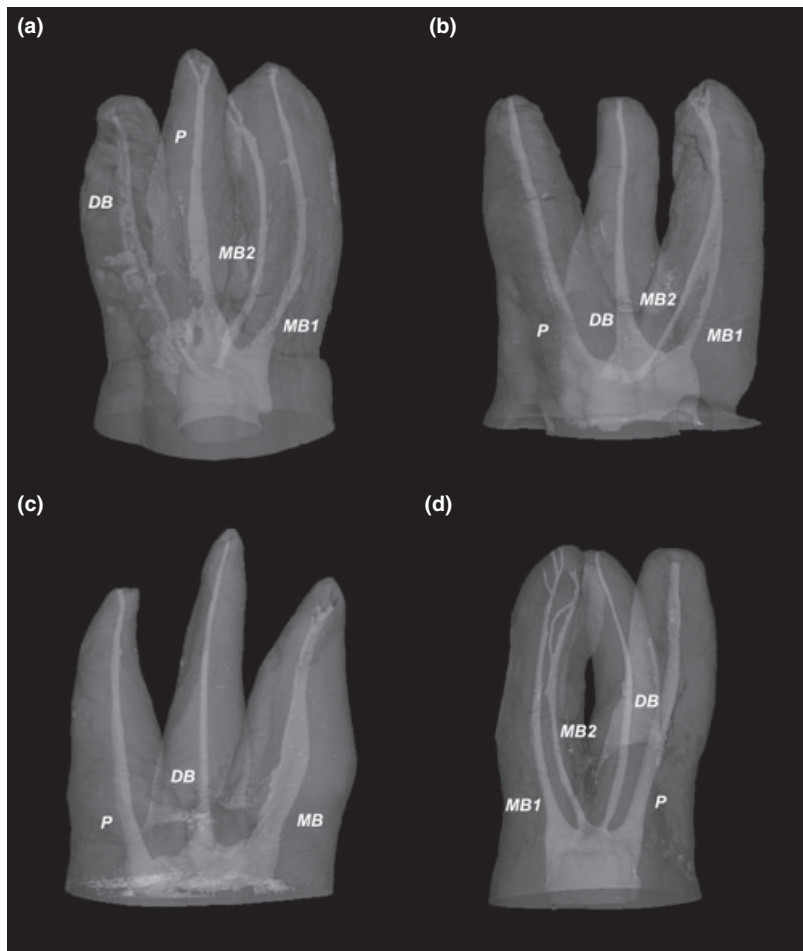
(a–d) Examples of maxillary first molar teeth obtained by micro-computed tomography imaging. Fig. 1a: completely independent mesiobuccal canal (MB2) canal. MB2 and palatal canals are further complicated by an accessory canal at the apex; despite the high resolution, the complete intercanal connection present between the middle and apical thirds were only partially reproduced. Fig. 1b: MB2 canal joining the MB1 canal in the middle third of the root, thus creating a wide 'lacuna' apically to the conjunction. Fig. 1c: a single canal in the mesiobuccal root, that is flattened in the coronal and middle thirds while showing a delta in the apical end. Fig. 1d: mesial root with two completely separate root canals. MB1 has two accessory canals at the apical end, while MB2 canal is further complicated by a loop in the apical third; despite the high resolution, the complete intercanal connections present in the middle and apical thirds were only partially reproduced.
